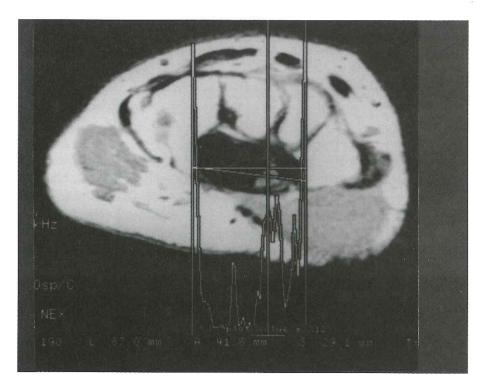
MRI of the distal carpal tunnel. A line plot is generated between the hook of the hamate and the base of the trapezium. The computer generates the pixel intensity for every structure along the line. The cursor (long vertical line through center of median nerve) is positioned to obtain the pixel intensity every 0.4 mm along the line. Note the pixel intensity of 312 generated through the center of the median nerve.
